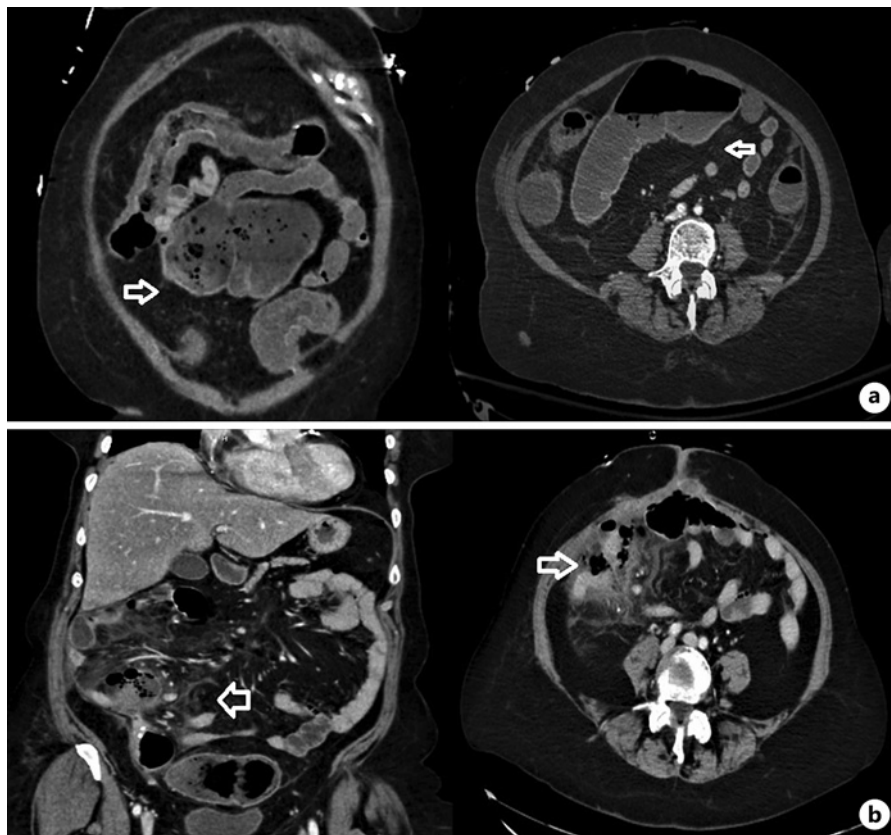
CT images during emergency department presentations. a Coronal and axial images from the first presentation showing fecal impaction, a redundant cecum, and thickened colon wall (white arrow). b Coronal and axial images from the second presentation showing small bowel phlegmon formation, pneumoperitoneum, and pneumatosis intestinalis (white arrow).
